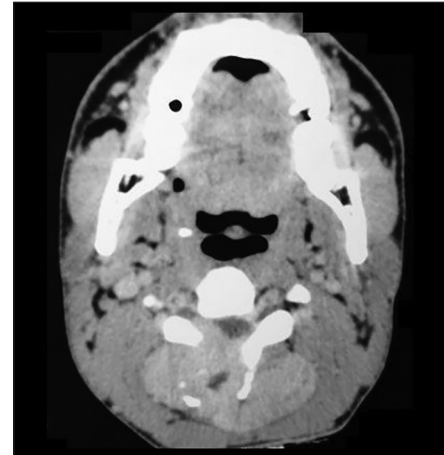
Axial view of computed tomography scan of the cervical spine revealing a hyperdense well-defined soft tissue mass eroding the right half of C3 lamina
